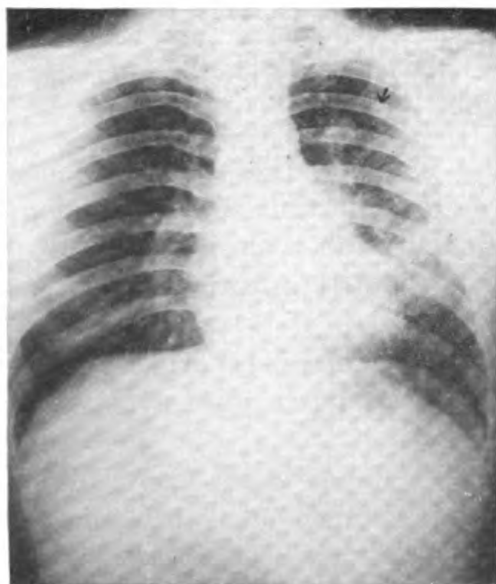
X-ray of chest in November 1944. Infiltration of left lung from second to fifth interspace, with cavity (1 cm.) at lower border of second rib (as indicated by arrow). Further diffusion of shadow at left hilar region.
